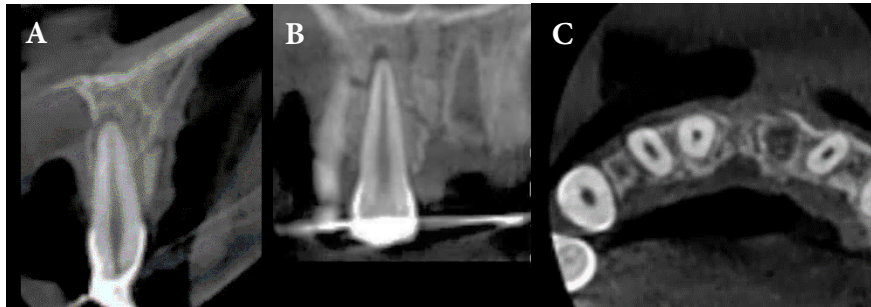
Preoperative CBCT views of the traumatized region: A) Sagittal; B) Coronal; C) Axial view
